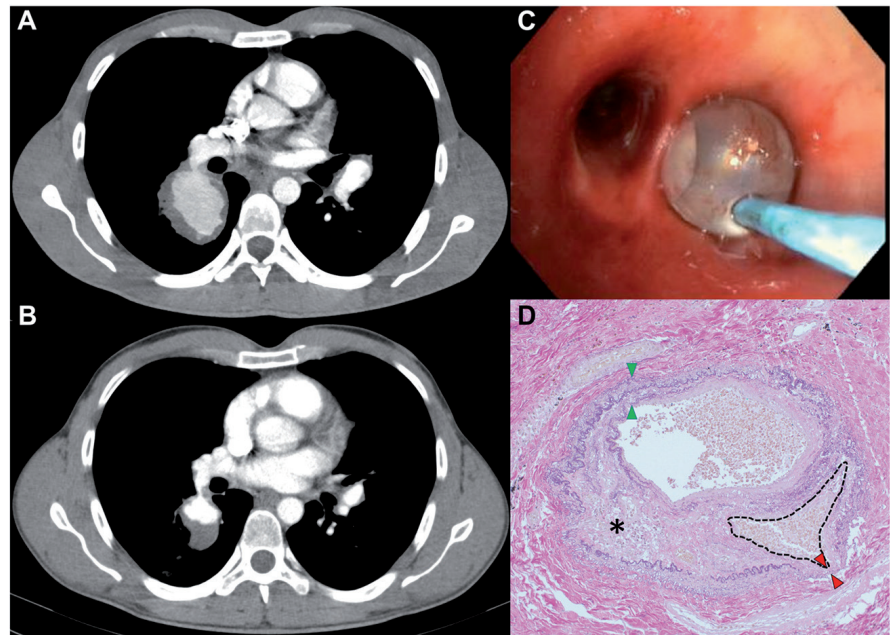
A: Computed tomography (CT) scan of the chest (axial, contrast enhanced): bilateral pulmonary artery aneurysm (right PAA: 53 x 43 mm, left PAA: 36 x 19 mm) with intra-luminal thrombosis prior to immunosuppressive therapy.
